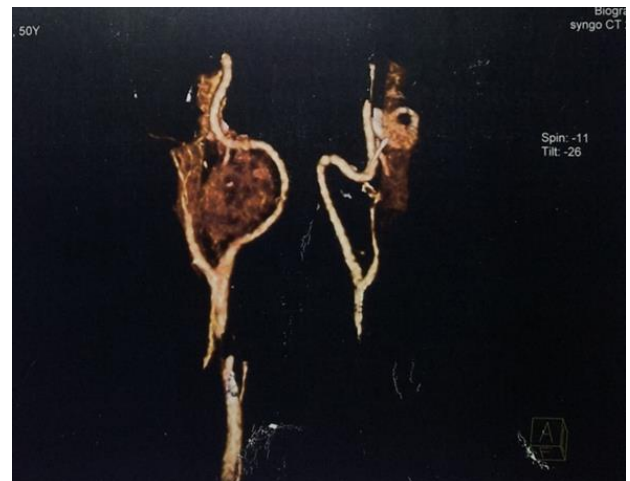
(CT carotid angiography)
